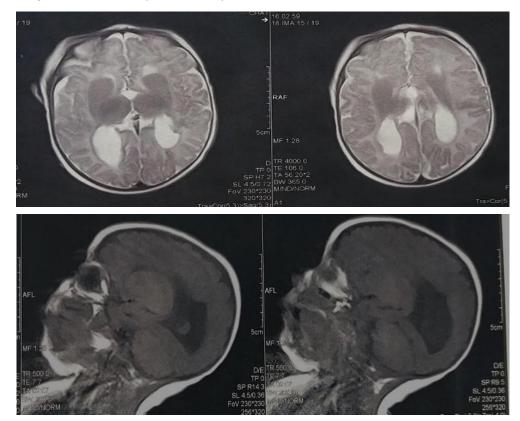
Cerebral MRI showing a separation of the lateral ventricles with colpocephaly in connection with agenesis of the corpus callosum
